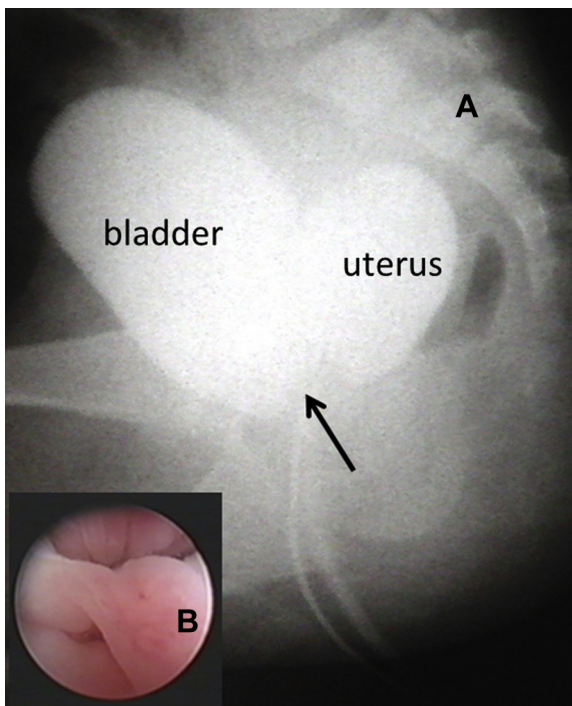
X-ray genitography showing dilated uterus, bladder and urogenital sinus high confluence (arrow) (A). Endoscopic appearance at confluence (B).
